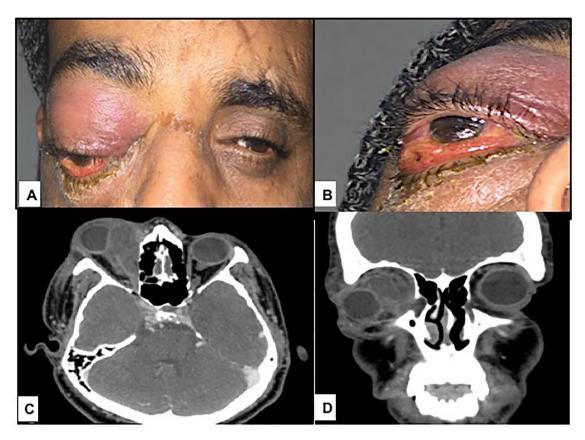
A & B: External photograph showing right eye dystopia and proptosis, right upper and lower eyelid edema and erythema and conjunctival chemosis. C & D: Axial and coronal CT of the orbit with contrast showing dilatation of the right lacrimal sac, a large extraconal non-enhancing fluid collection seen adjacent to the right medial rectus muscle and causing mass effect on the globe.
